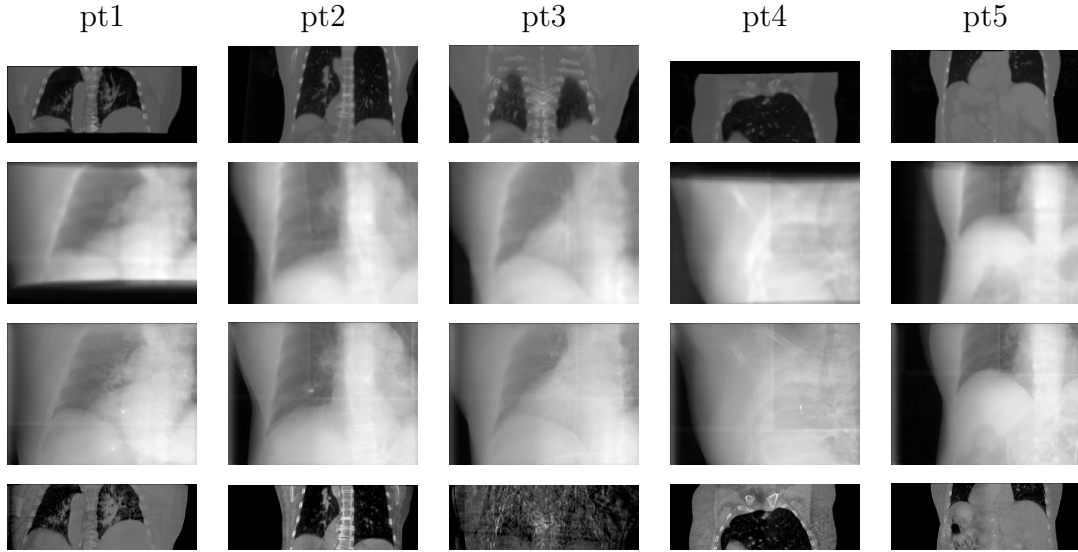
The 5 lung datasets. Top row: the middle coronal slices of the patients' Fréchet mean CT images. Second row: DRRs of the Fréchet mean CT images. Third row: target projection images at the end-of-expiration (EE) phase. Fourth row: validating reconstructed cone-beam CTs (CBCTs) at the EE phases.
